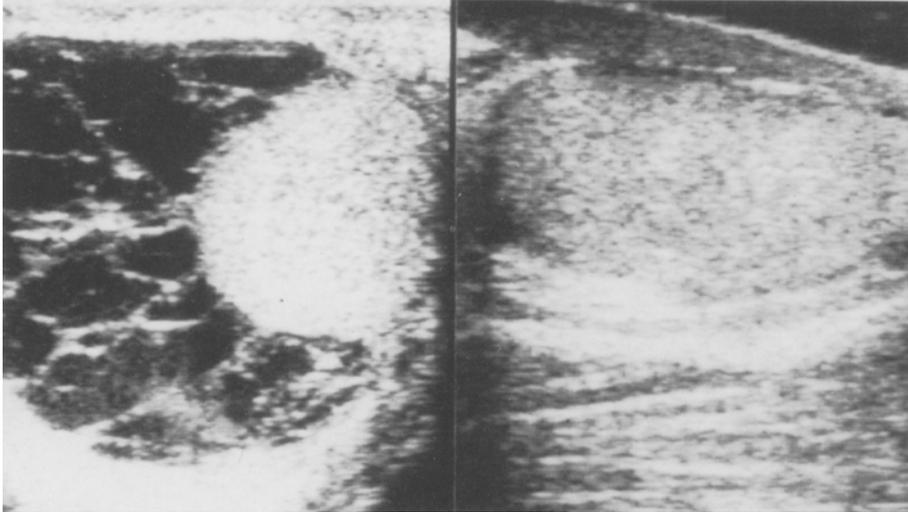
Left: Ultrasound one month after sclerosing shows multilocular cystic recurrence. Right: Normal scrotal ultrasound two months later
